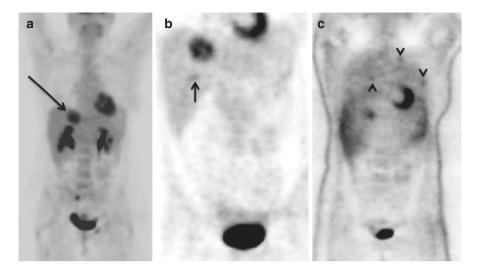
Role of dual time point FDG PET-CT. 70-year-old female with colorectal cancer and known solitary liver metastasis presenting with rising CEA levels. Conventional imaging confirmed the known solitary hepatic metastasis but failed to demonstrate any evidence of disease progression to explain the rising CEA levels. Routine FDG-PET 1 h post injection (a) also demonstrates a solitary FDG avid hepatic lesion (long arrow). Delayed FDG PET performed at 2 h (b and c) post injection however demonstrates a further suspicious FDG avid hepatic lesion (short arrow in b) and several pulmonary micro-nodules with increased FDG uptake which are better seen on the non-attenuation corrected (NAC) images (arrow heads in c)
